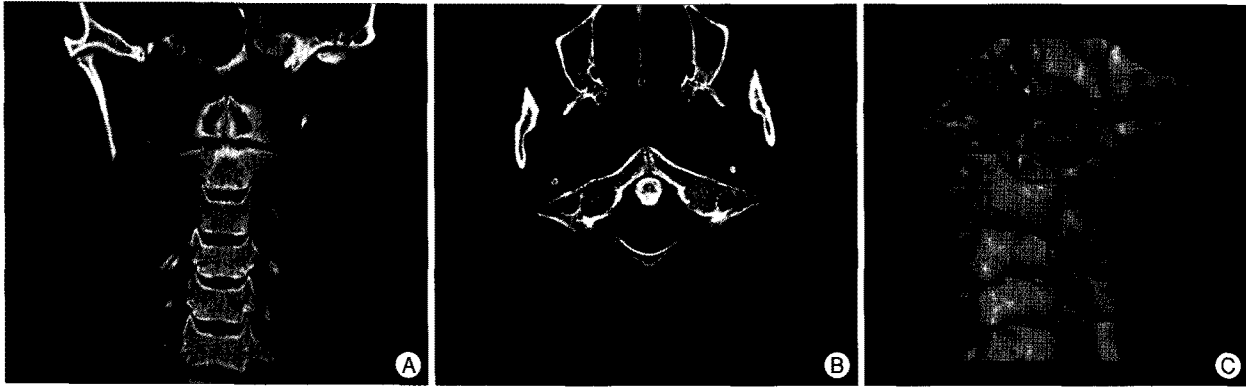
A CT scan reveals a midline cleft in the anterior arch of the atlas (A) and partial aplasia of the posterior arch (B and C).
